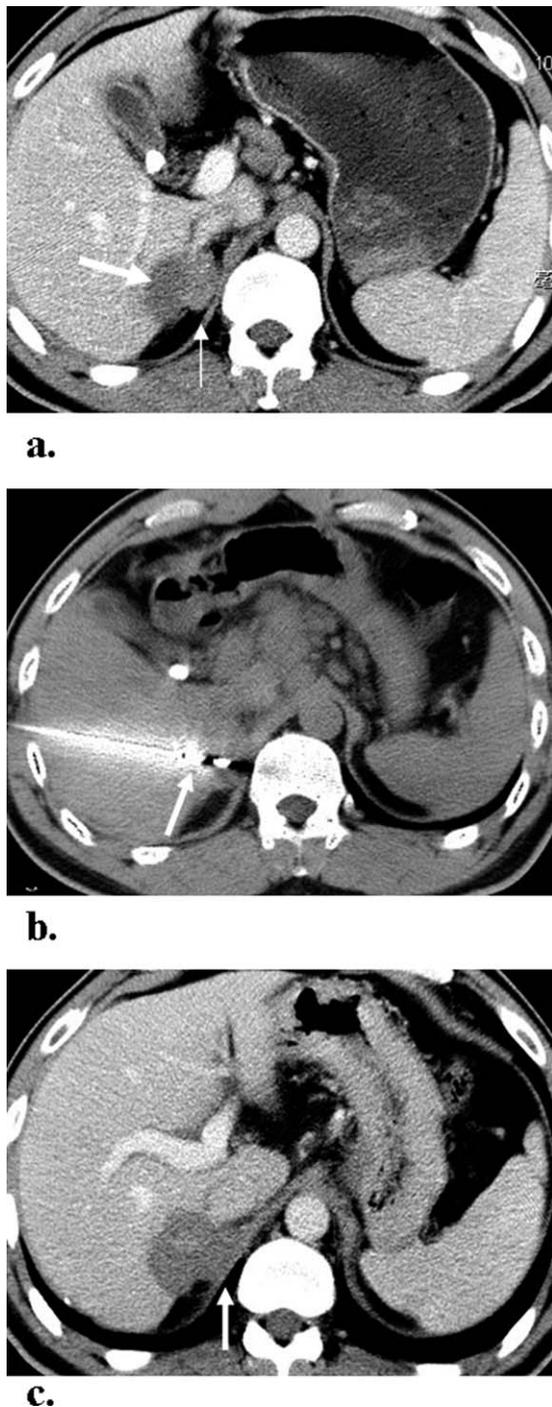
A male patient with intrahepatic cholangiocarcinoma involving the right lobe of the liver with isolated metastasis in the right adrenal two months after microwave ablation, with tumor size of 3.6×1.8 cm. (a) Enhanced CT scan on abdominal transverse section shows a low density primary tumor (thick arrow), which resulted from the ablation. (b) In the supine position, the patient receives the microwave ablation antenna in the tumor center under CT guidance (arrow indicating the microwave antenna). (c) There was no enhancement 3 months after the treatment, as revealed by enhanced CT scan.
